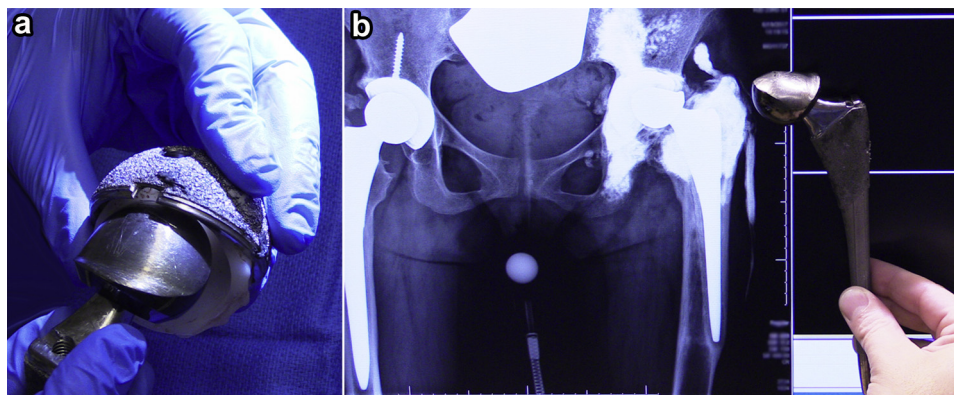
(a) Intraoperative gross image demonstrating flattening of the femoral head caused by probable dissociation of the liner and erosion of the femoral head on the metallic rim of the acetabular component. (b) Intraoperative comparison of retrieved implant alongside the preoperative anteroposterior pelvis radiograph.
